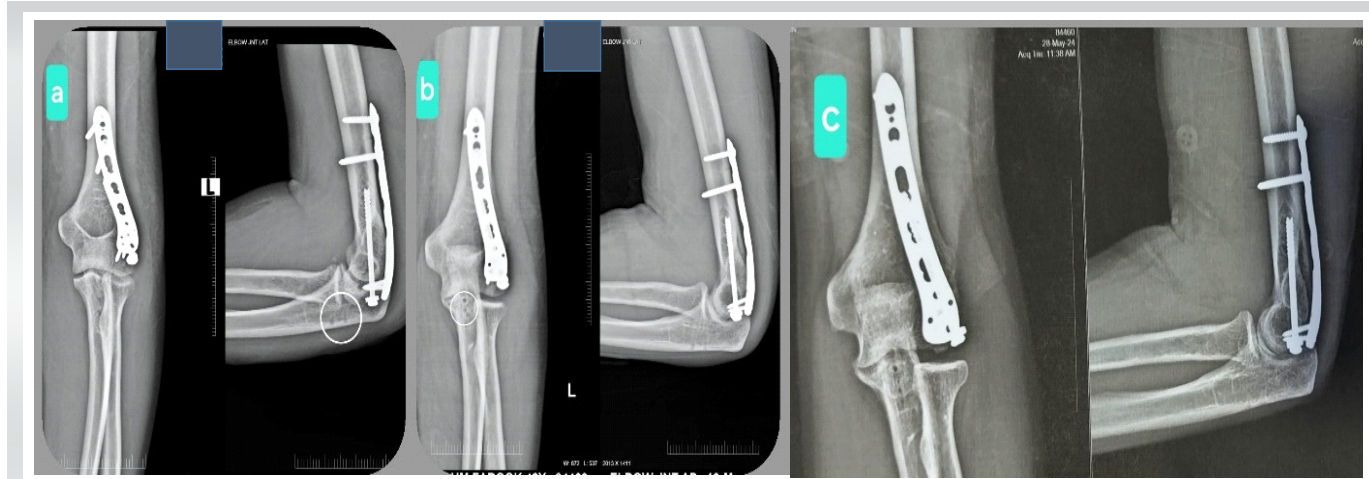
Post-operative X-rays. (a) immediate post-operative X-ray. (b) 4-week post-operative X-ray. (c) 1-year post-operative X-rays. White circle in (a and b) image shows drill holes for lasso stitch for the anterior capsule.
